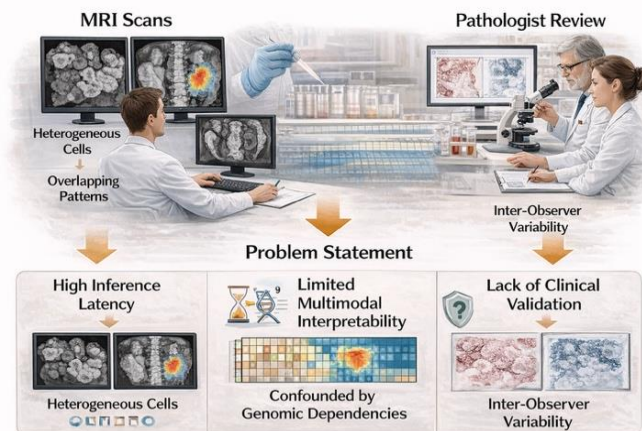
Key problems in bone marrow cancer diagnosis using MRI Scans and Pathologist reviews
